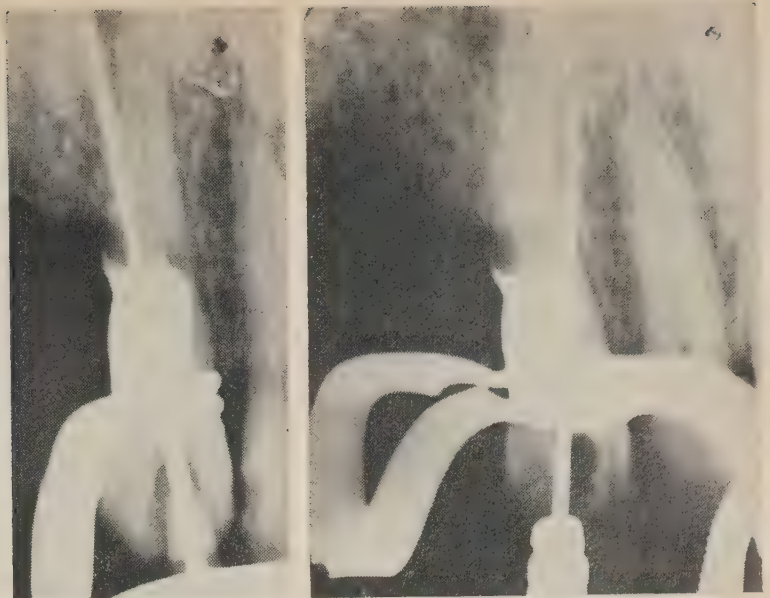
Radiographs showing mesial and distal perforation of the cuspid root.
